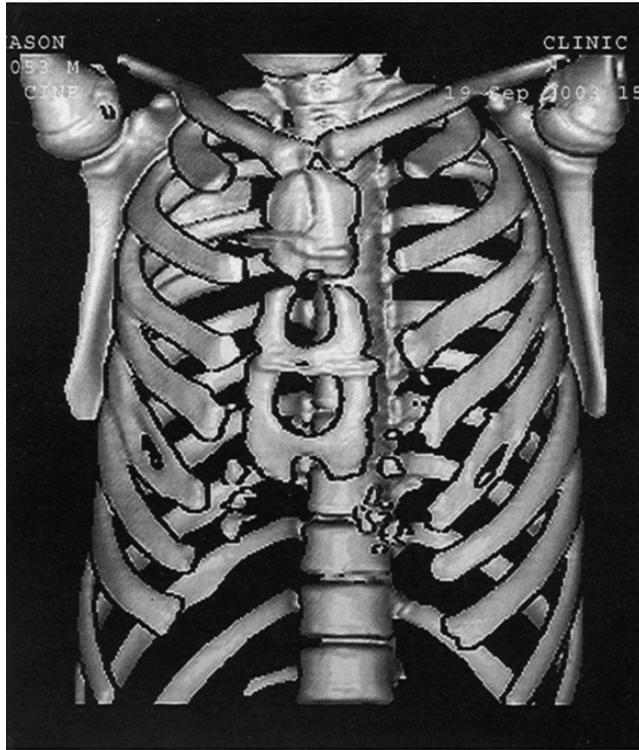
Reconstruction of a CT scan performed 1 year postoperatively in a child with ATD showing complete healing of three rib grafts separating the sternal halves (36).
